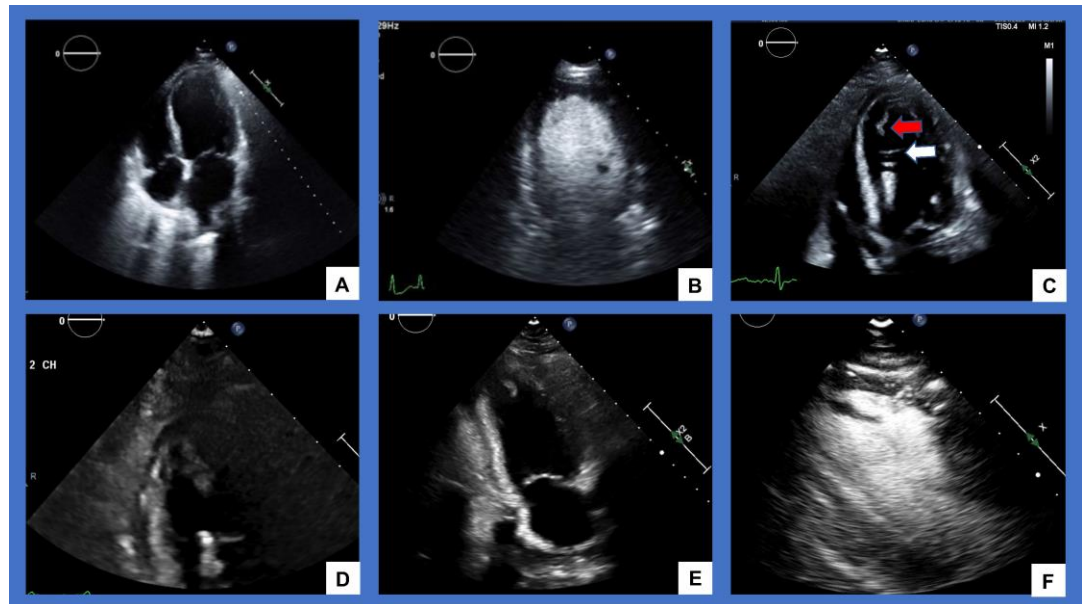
A) This is an Apical 4 chamber view of transthoracic echocardiogram (TTE) before deployment of the Impella CP. No left ventricular (LV) thrombus is seen. B) Definity® ultrasound contrast is used in this view and again demonstrates absence of LV thrombus. C) The tip of the Impella (white arrow) and apical mobile LV thrombus (red arrow) are identified. D) This is a close up image of the LV thrombus and tip of Impella. E) This TTE is 48 hours after Impella removal and F) is the same image with Definity ultrasound contrast. There was a similar finding six days post-Impella removal prior to discharge.
